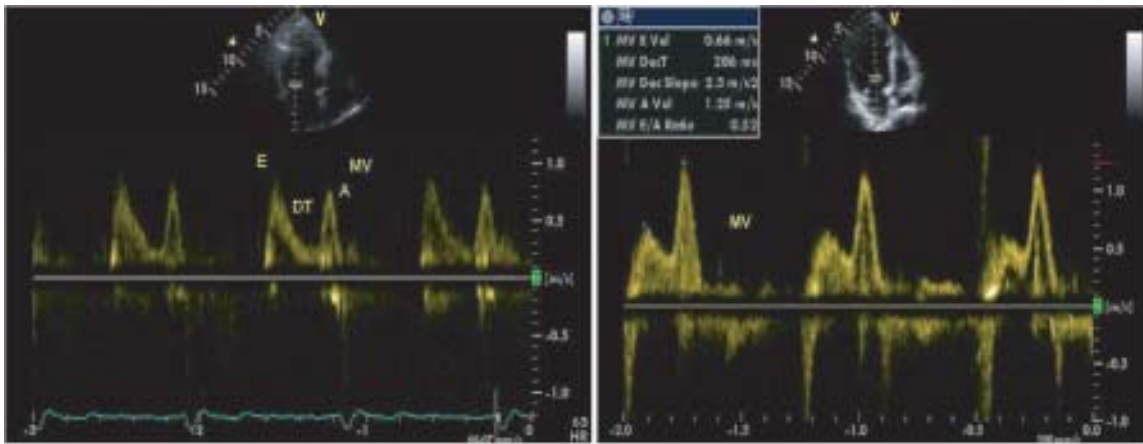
Normal Pulsed Wave Doppler (left panel), and Grade-I left ventricular diastolic dysfunction (right panel).
